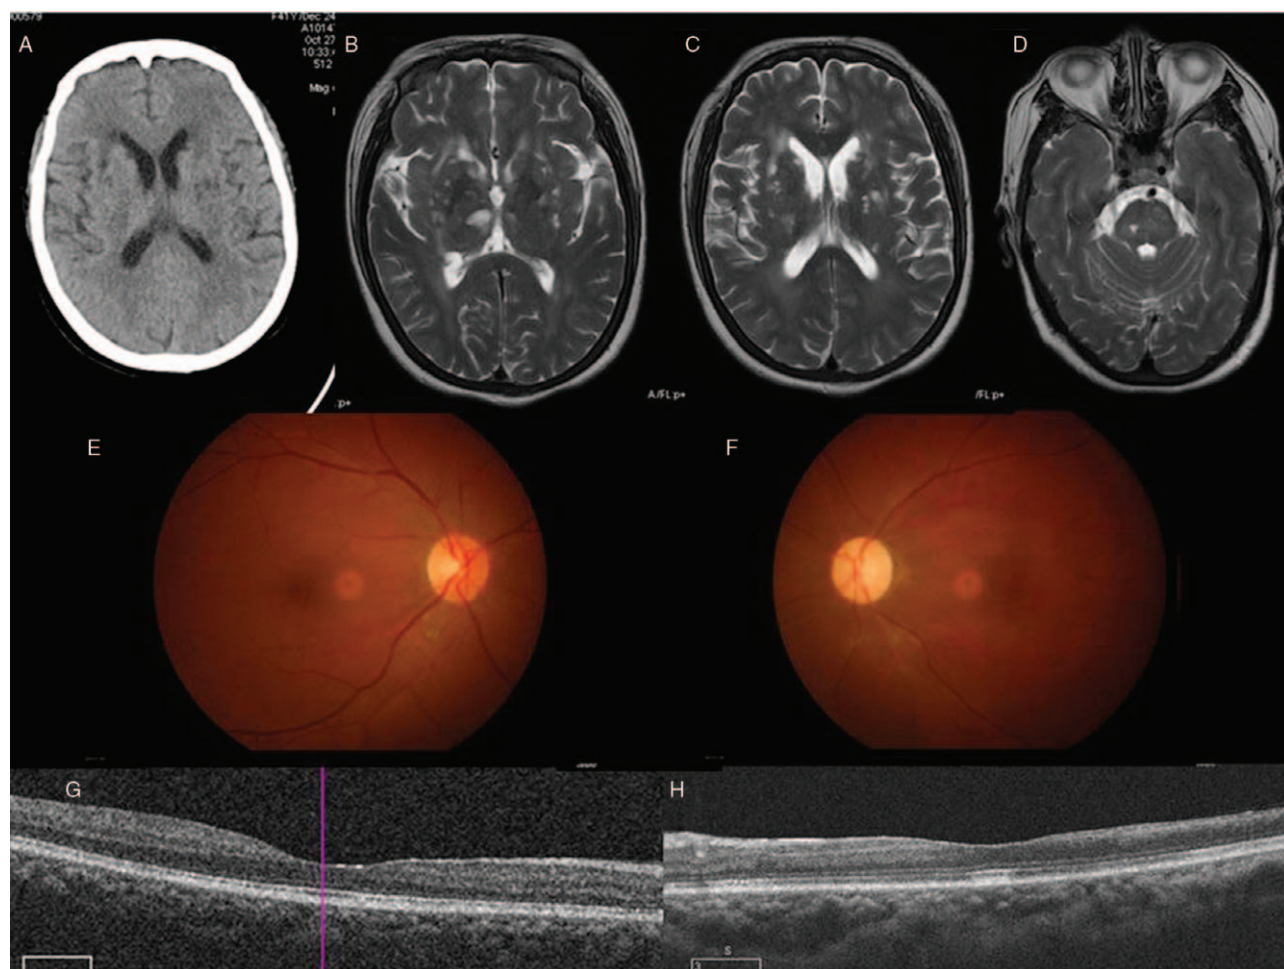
Representative image of the patient. (A) CT scan indicated multiple small hypointense lesions existed in bilateral basal ganglia and pons. (B, C) Magnetic resonance images showed there were multiple hyperintense lesions on T2 in the periventricular area (right thalamus dorsalis and bilateral basal ganglia). (D) It showed an old hyperintense lesion in pons. (E) The fundus of the right eye showed there was some spot-like hard exudation around the inferior temporal branch artery. (F) It presented that blocked arterioles could be seen in all of the branches of retinal artery periphery in the left eye. (G) OCT of the right eye showed no abnormalities. (H) OCT indicated that the inner retinal layers became thinner and the ellipsoid zone of the macular area and the outer segment of the photoreceptor cells showed high reflection in the left eye. CT: Computed tomography; OCT: Optical coherence tomography.
